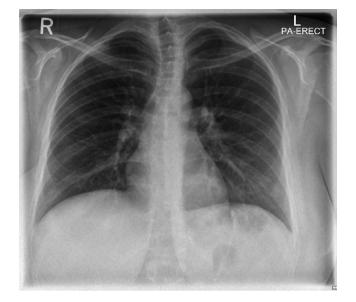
Chest X-ray on admission to the ward
